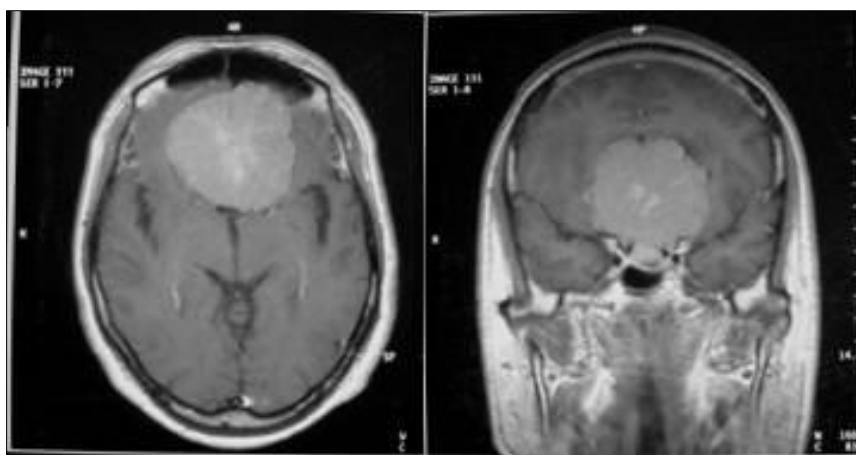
Cerebral MRI in T1 sequence after intravenous contrast injection, in axial section (left) and coronal section (right) showing an anterior stage meningioma
